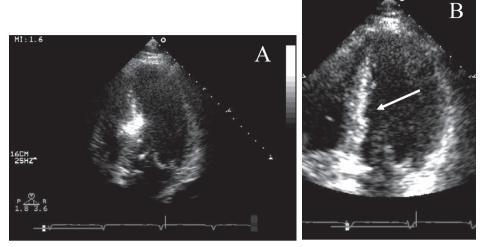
Panel A. Two-dimensional echocardiogram during PTSMA. 1.5 ml Sonovue® is injected into the targeted septal branch under continuous monitoring of 2D echo. The targeted myocardium is shown as an opacification of echo contrast in the myocardium. For further explanation, see text.
